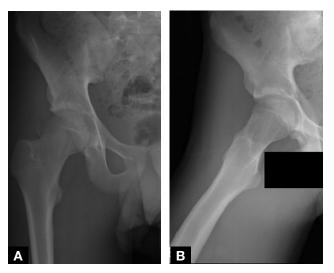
Case 1: Preoperative anteroposterior (A) and frog-leg lateral (B) radiographs of right hip after closed reduction show concentrically reduced hip with loose osteochondral fragment and irregularity of femoral head.
